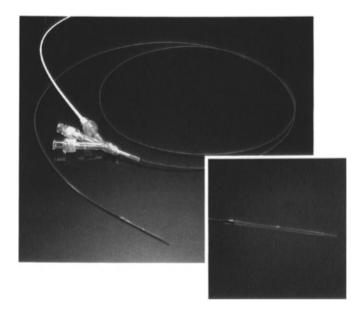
Oracle Micro diagnostic ultrasound catheter within therapeutic coronary angioplasty balloon catheter.
